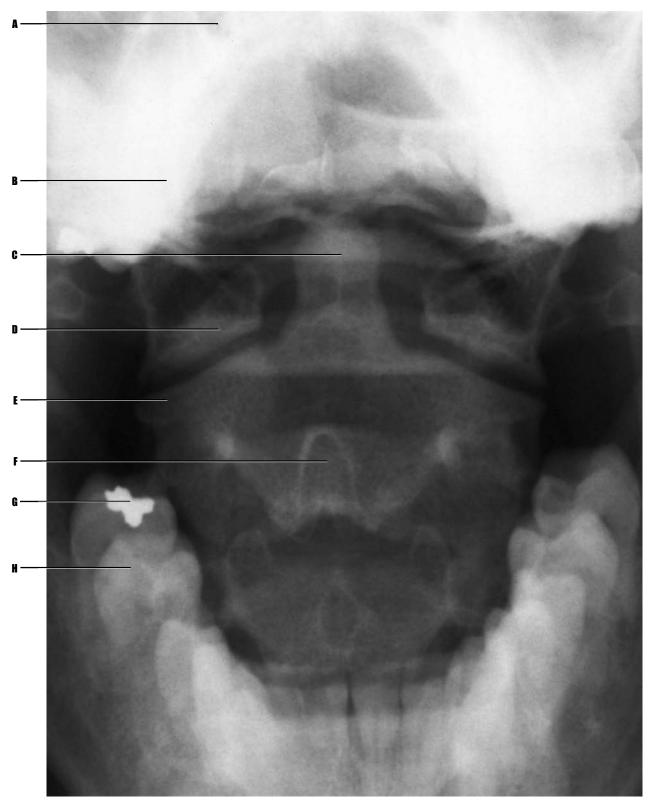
Adult patient, plain film radiograph, "odontoid view" through open mouth.
